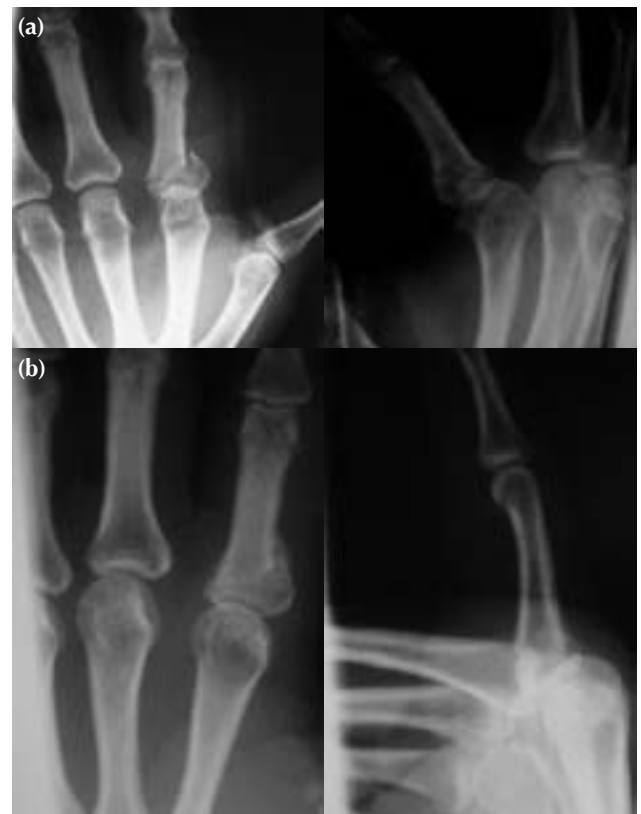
(a) Preoperative radiographs showing a comminuted proximal phalangeal fracture of the ring finger. (b) Postoperative 7-week radiographs showing bone union after dynamic treatment.
